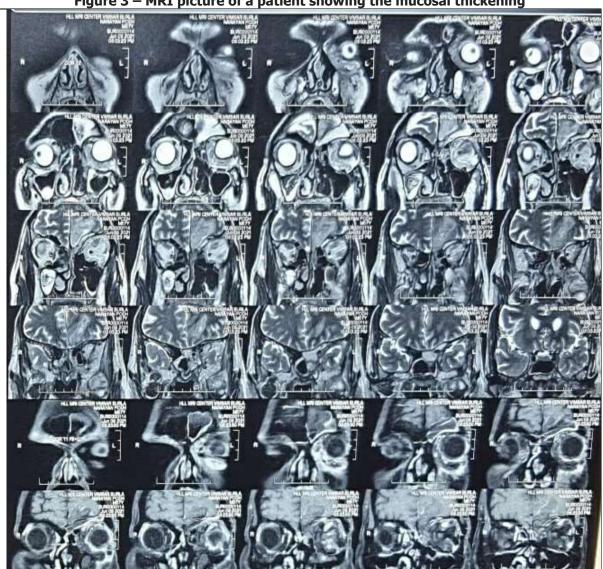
MRI picture of a patient showing the mucosal thickening
